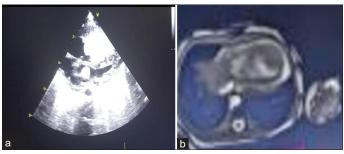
(a) 2D Echo – Multiple homogenous, intra cardiac masses in right and left ventricular apex, left ventricular post wall, inter ventricular septum and sub aortic valve suggestive of rhabdomyoma and (b) Cardiac magnetic resonance imaging - Right ventricular Rhabdomyoma 3  $\times$  2.4  $\times$  2.6 with right ventricular outflow tract obstruction, intra cavitary lesion 95 mm along left ventricular lateral wall and 6 mm lesion in the left ventricular out flow tract causing left ventricular outflow tract obstruction
